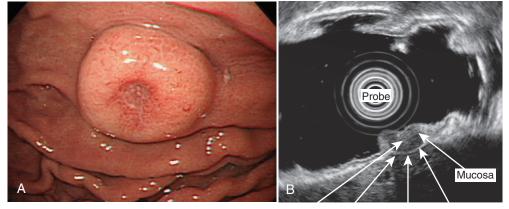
Gastric carcinoid tumor. A, Endoscopic image of a round, umbilicated, submucosal lesion in the gastric body. B, Endosonographic view of a homogeneous, hypoechoic, umbilicated mass within the second sonographic layer.
